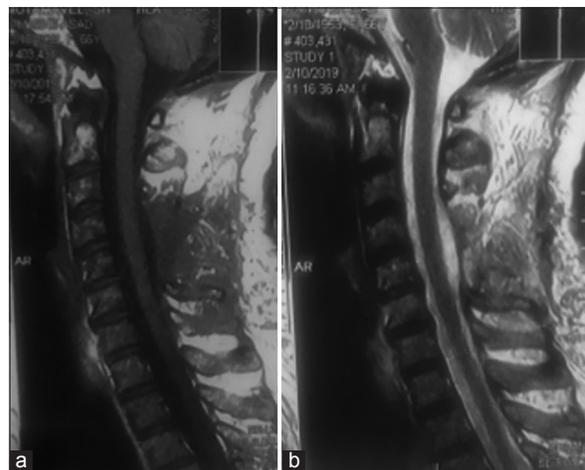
Postoperative magnetic resonance imaging (MRI): (a) T1-weighted and (b) T2-weighted cervical MRI shows acceptable decompression of the cord.
